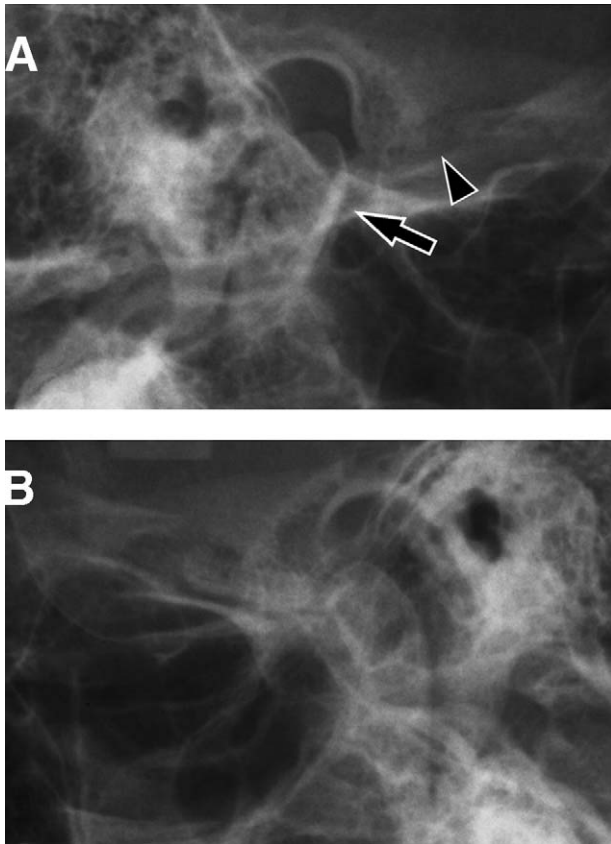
Schuller method radiographs in the position of opening the mouth. Limitation of the condylar movement is seen in the right (A, arrow) compared to the left (B). There is no sign of fracture in the articular eminence (A, arrowhead).
